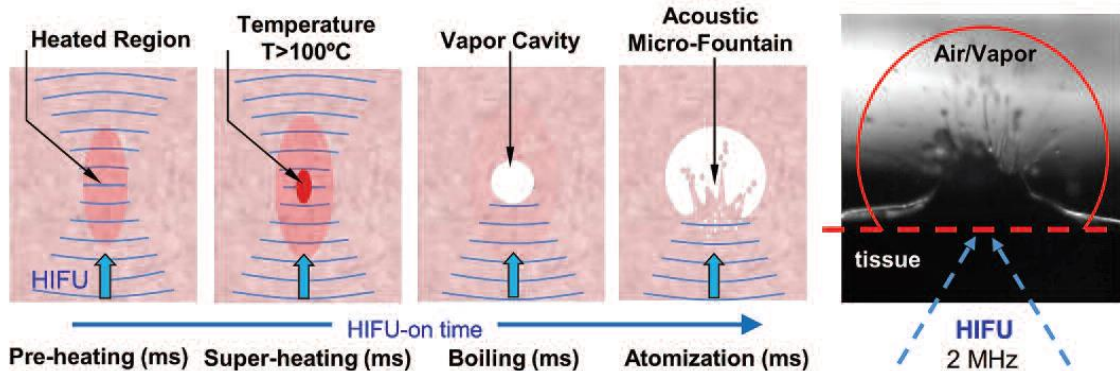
Focused ultrasound heats a region of tissue, and at the focal center, nonlinear heating leads to rapid temperature increase and a vapor cavity forming at boiling. This vapor cavity expands, providing a reflector for follow-up acoustic waves to generate an acoustic fountain effect, leading to mechanical ablation of tissue in and around the vapor cavity. [38]. See Appendix A for Copyright Permission.
